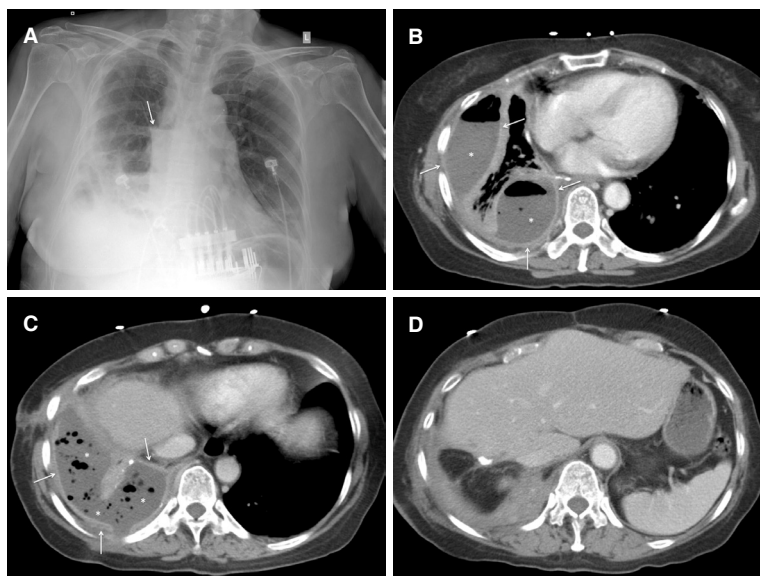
Chest radiograph and computed tomography (CT) showing empyema. The frontal chest radiograph (A) shows layering fluid in the right pleural space with an air-fluid level more medially, overlapping the right paramediastinal shadow (arrow) corresponding to the empyema. Enhanced axial CT images (B and C) show loculated fluid (asterisks) in the right pleural space with pockets of gas surrounded by a thick, enhancing rim (arrows) typical of an empyema. More caudally in the upper abdomen (D), hepatectomy changes are demonstrated post-resection of the previously noted large hepatic mass with regeneration of the left lobe
